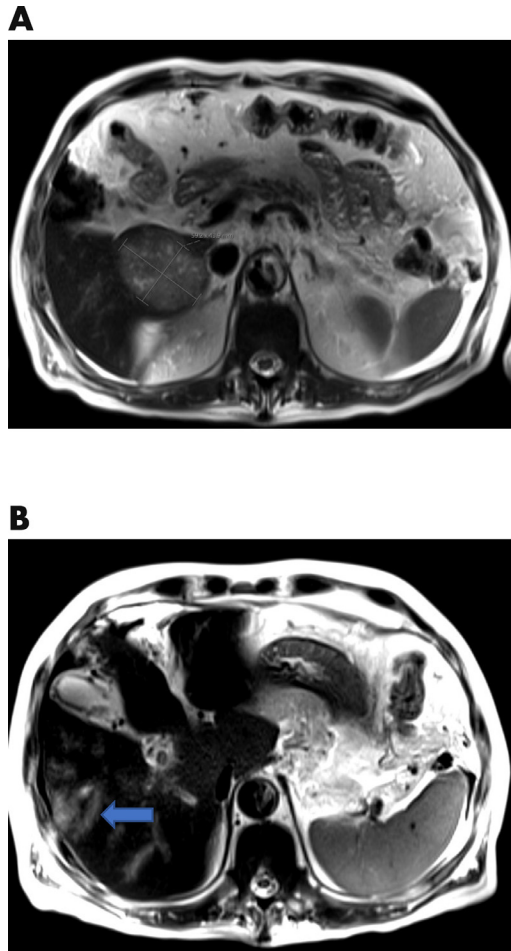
MRI liver with intravenous gadolinium contrast on axial T2 sequence showing moderately hyperintense 59.2 × 43.9 mm mass within hepatic segments 5 and 6 (A) and within segment 8 (B) along perivascular tracts (blue arrow).
